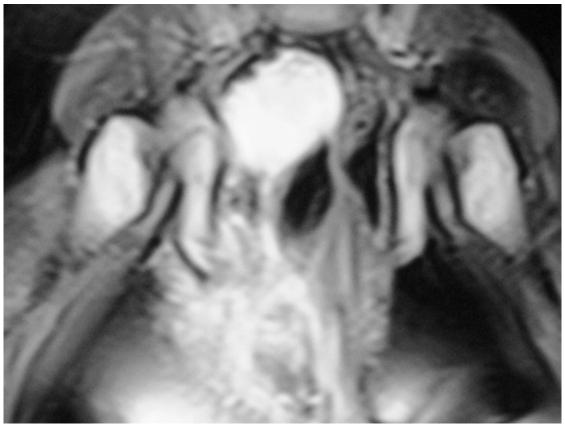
Coronal T2-weighted MR image shows pelvic origin of the solid tumor with high signal intensity. Note is infiltrating subcutaneous tissue.
